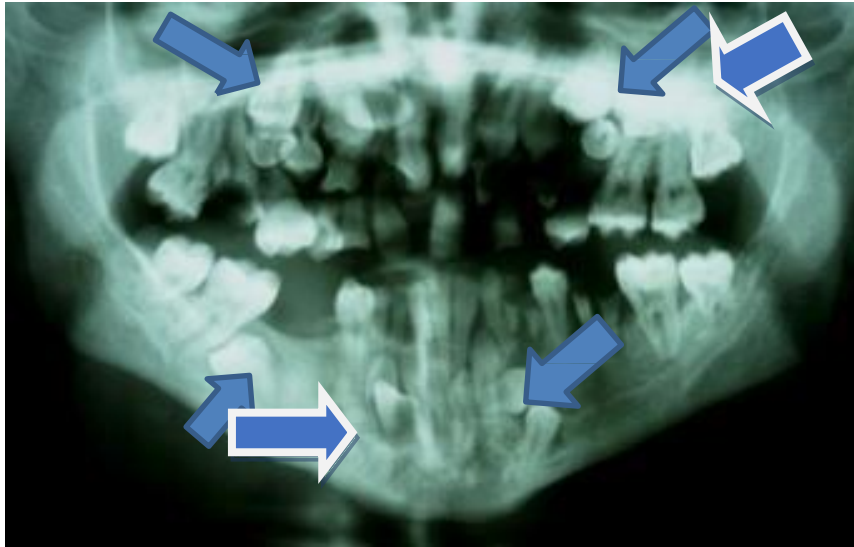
Multiple unerupted supernumerary teeth detected on orthopantomogram (blue arrows)
